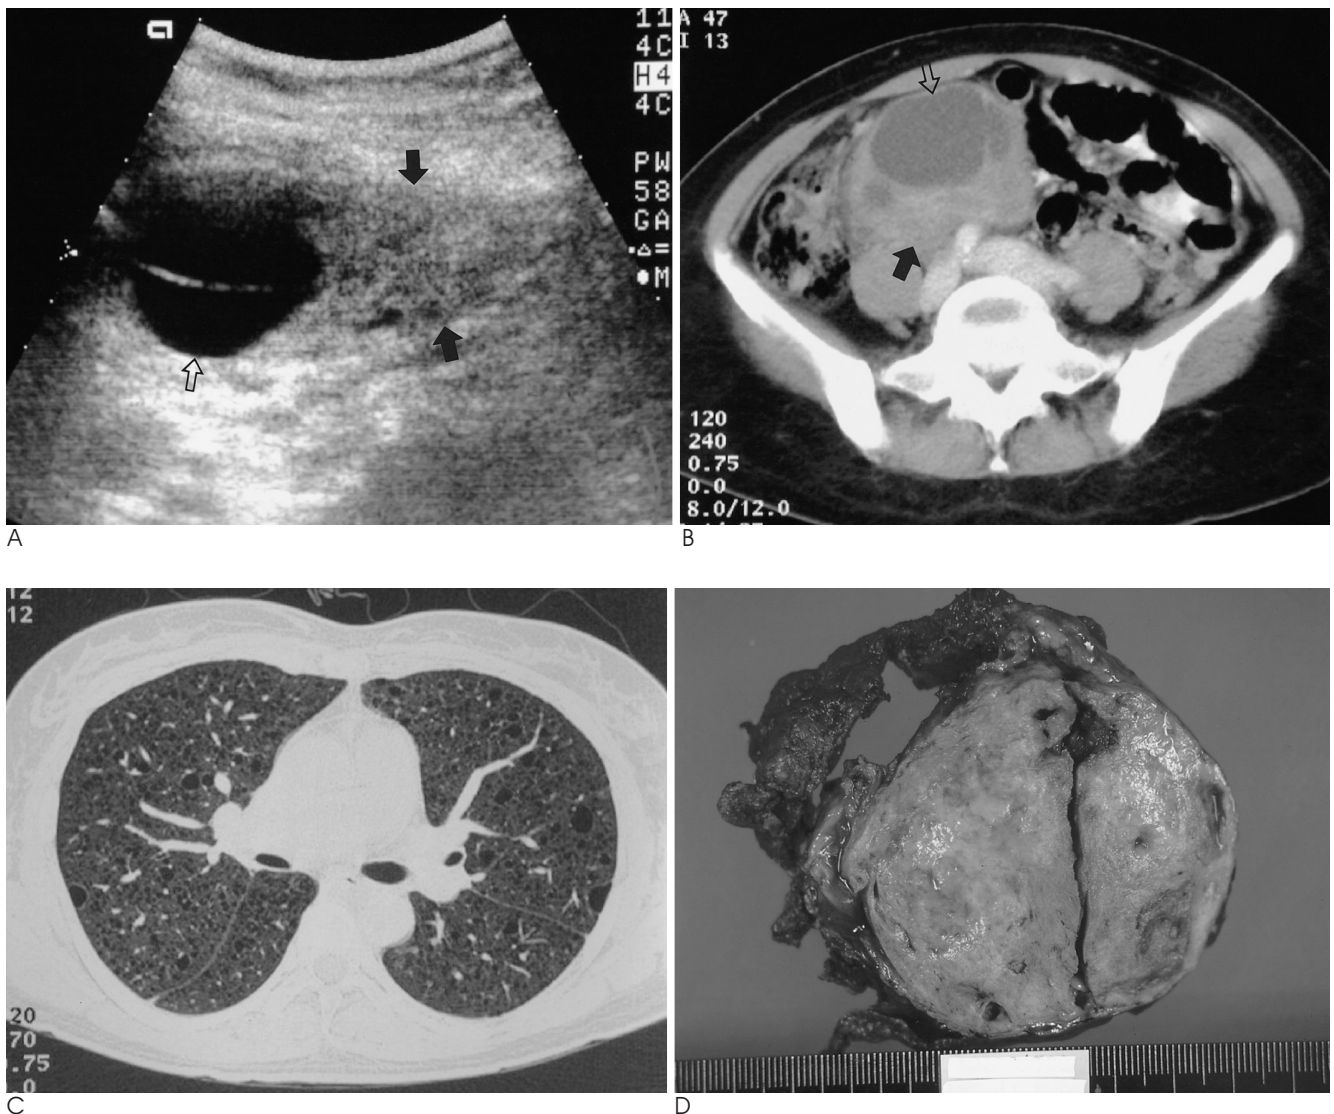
A. Ultrasonography shows about an 8.5 cm sized, well-defined mass with a septated cystic portion (open arrow) and an echogenic solid portions (solid arrows) in the longitudinal scan of the right lower abdomen.
